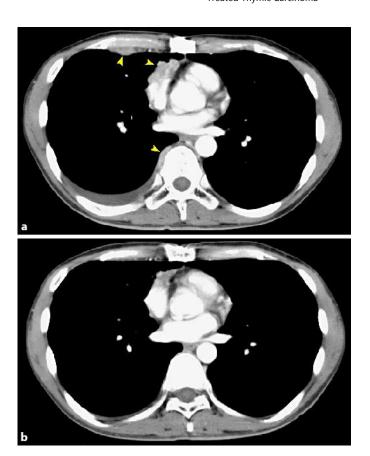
CT scans of the chest upon admission showed multiple disseminated nodules (indicated by arrowheads) with a pleural effusion in the right thorax (a). Tumor shrinkage was achieved and the pleural effusion disappeared after 4 cycles of *nab*-paclitaxel plus carboplatin (b).
